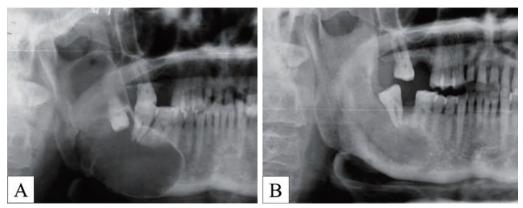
(A) Radiograph of large mandibular dentigerous cyst. (B) Six months after marsupialization.
